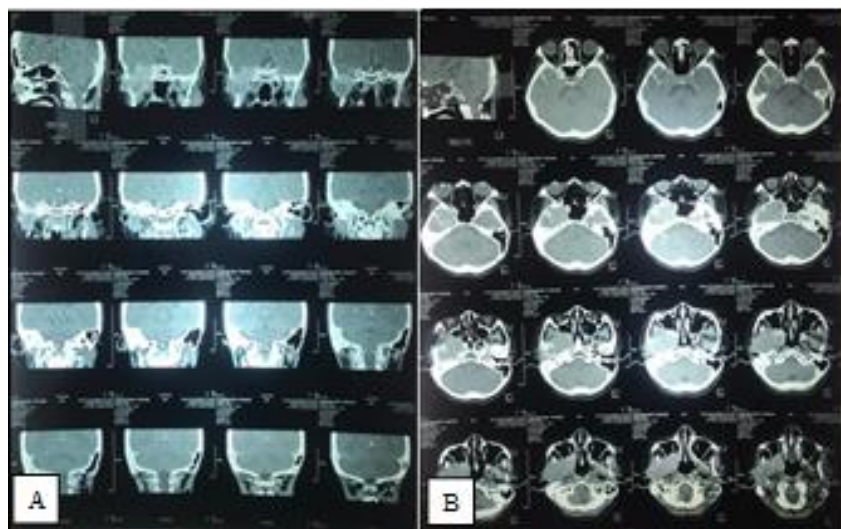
Mastoid CT-Scan. CT-Scan showed a mass in right external auditory canal with destruction of the tympanic segment (A) Coronal section. (B) Axial Section.
